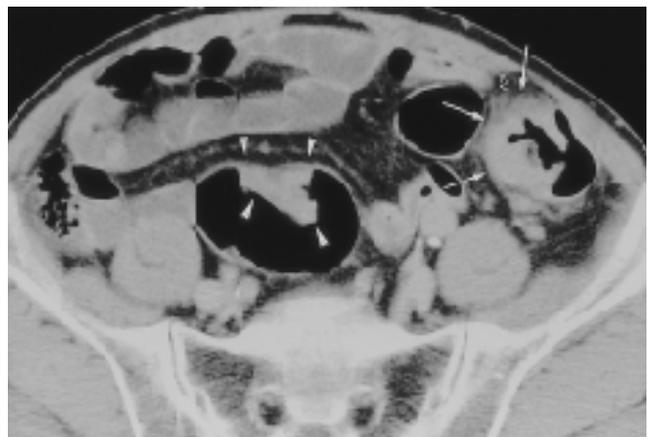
Air enema CT scan. Synchronous colon cancer with different stage is well visualized. CT scan shows circumferentially thickened, lobulated mass at descending colon(arrows). Soft tissue densities are seen in adjacent pericolic fat suggesting T3(open arrow). Pathologic examination revealed tumor invasion into pericolic fat(T3). Another sharply defined polypoid mass is identified at sigmoid colon(arrowheads). It is sharply defined without peritumoral infiltration suggesting T2. Pathologic examination revealed tumor invasion limited into muscularis propria(T2).
